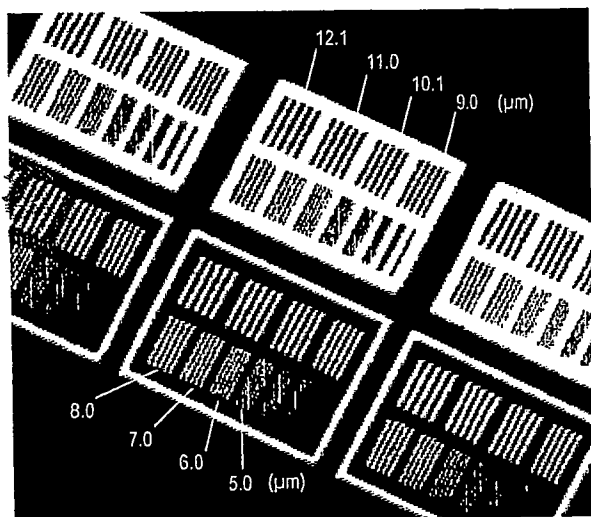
X-ray image of the central area of the 5- μm -thick chart. Numerical values show bar widths. The limiting spatial resolution is around 6.0 μm .
